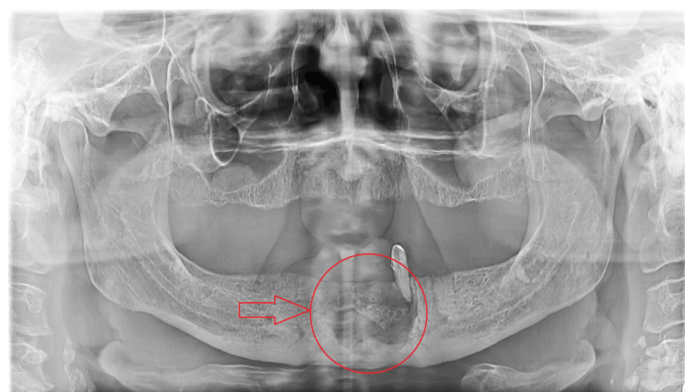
Radiographic exam (OPG) shows a region of mottled bone with a central sequestrum in the left (L) anterior mandible. OPG: Orthopantomogram.
